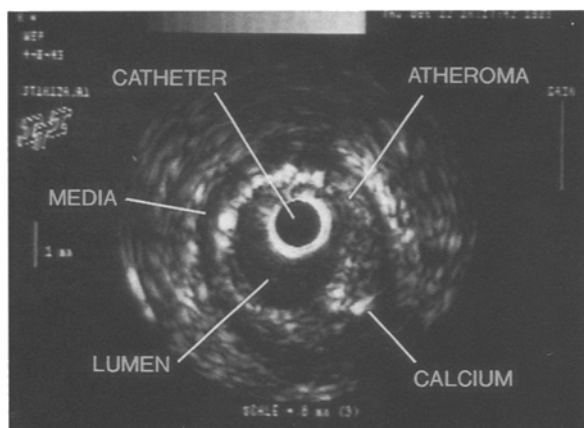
A representative intravascular ultrasound image of the mid LAD. This ultrasound image was taken from a section of the artery that appeared normal on angiography. (Reprinted with American Heart Association's permission.).
